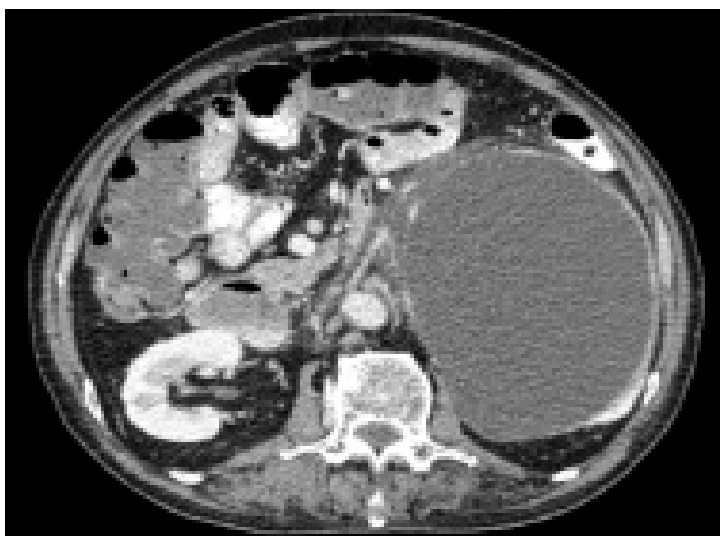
Contrasted computed tomography showing left huge homogenous and regular retroperitoneal lesion with peripheral enhancement on axial view
